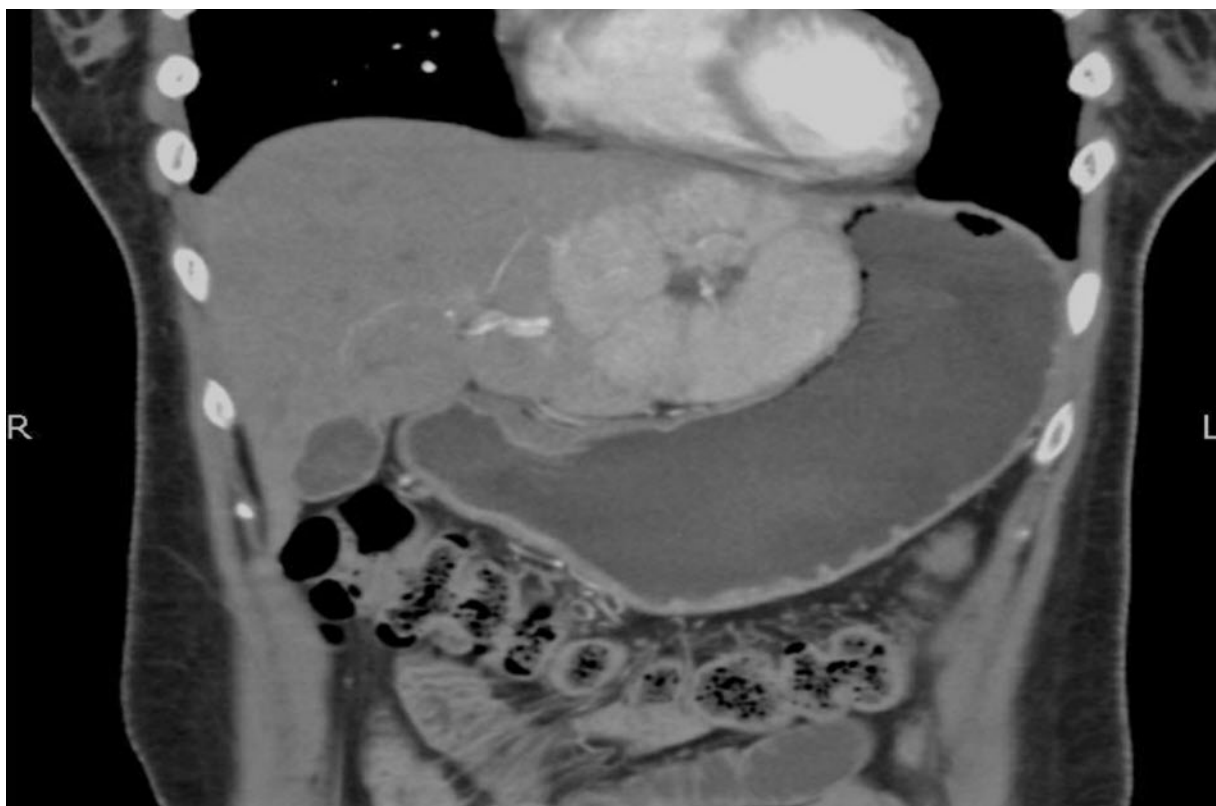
Contrast enhanced CT scan showing a well circumscribed lesion in the left lobe with a central hypodense stellate scar
